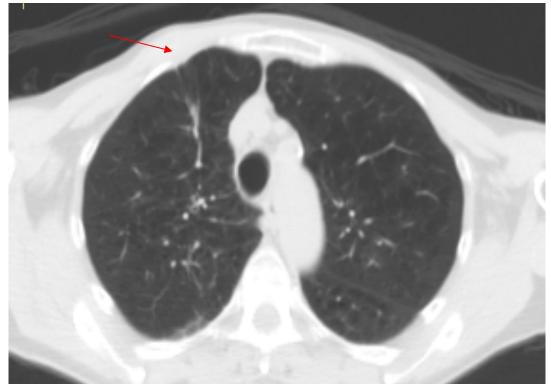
Axial CT scan showing healing of bronchopleural-subcutaneous fistula and complete resorption of the fibrin glue [arrow].
